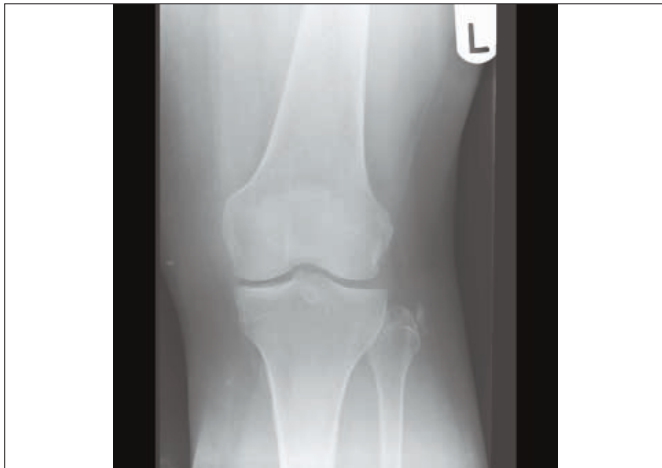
Plain X-ray of the left knee showing lateral collateral ligament calcification.
